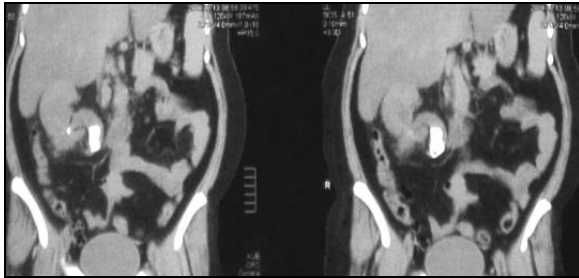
Right renal specks of air seen on non-contrast computed tomography imaging
